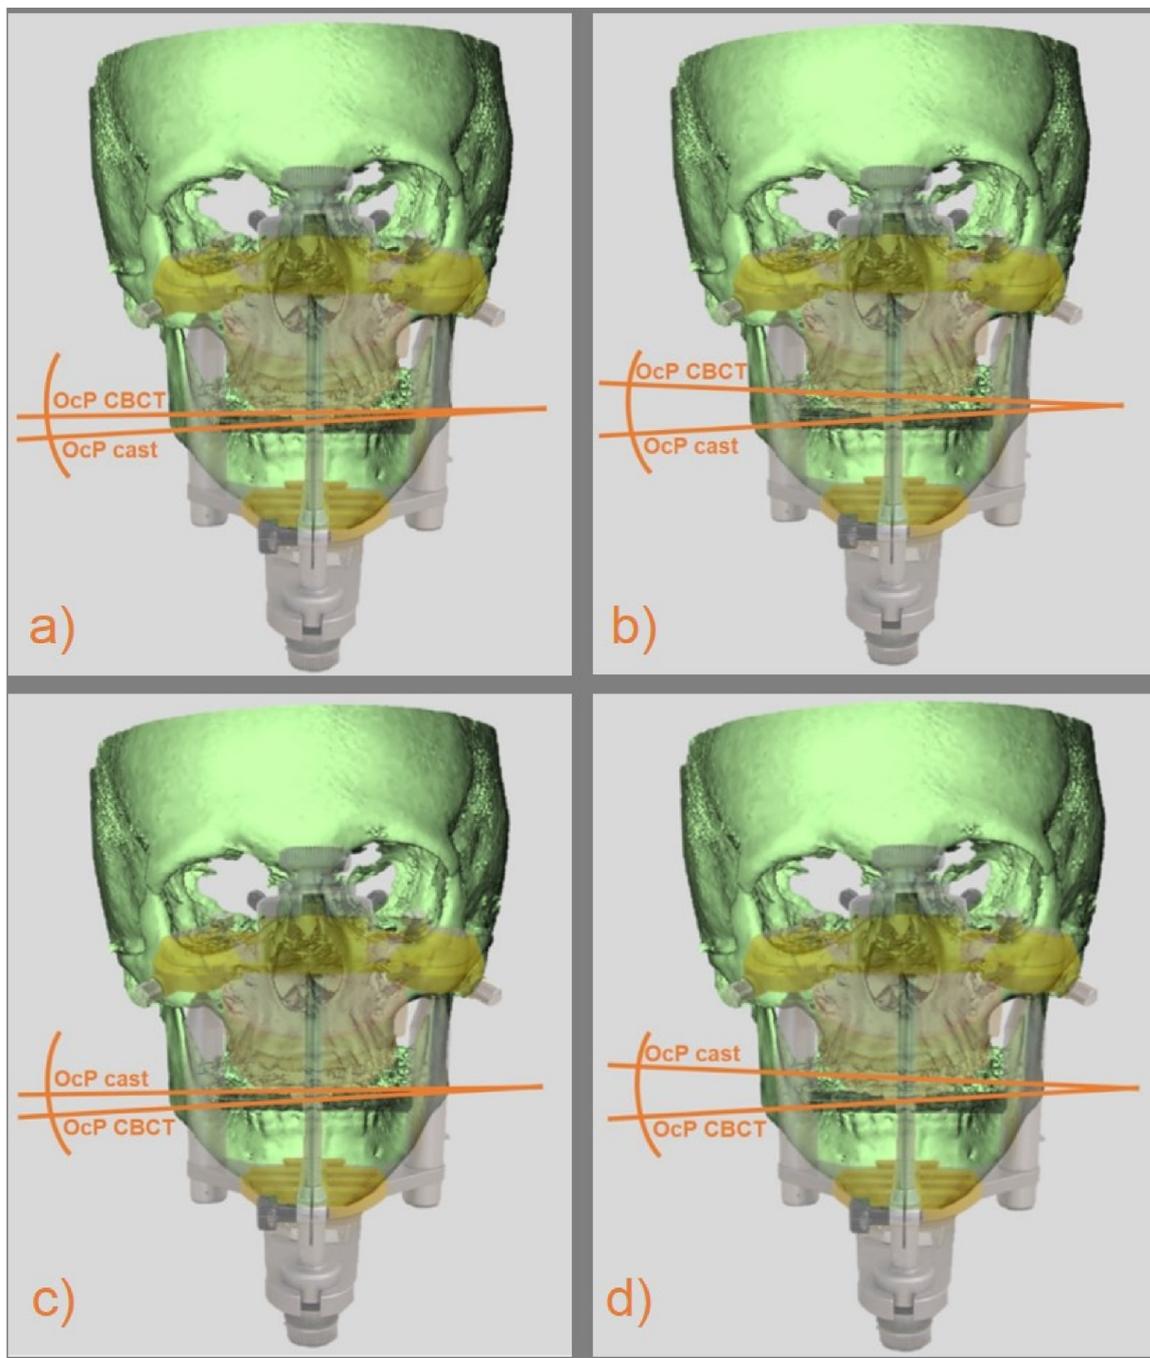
The articulator-based method failed to reproduce maxillary canting correctly. The occlusal plane of the plaster casts in the articulator (OcP cast) either concealed or increased the transverse roll of the maxilla like it was reproduced in the compared to the occlusal plane reproduced in the CBCT (OcP CBCT). Four types of error in the articulator-based model were found to be possible when compared to the computer-based model: (a) higher angle and same roll, (b) higher angle and opposite roll, (c) lower angle and same roll, and (d) lower angle and opposite roll.
